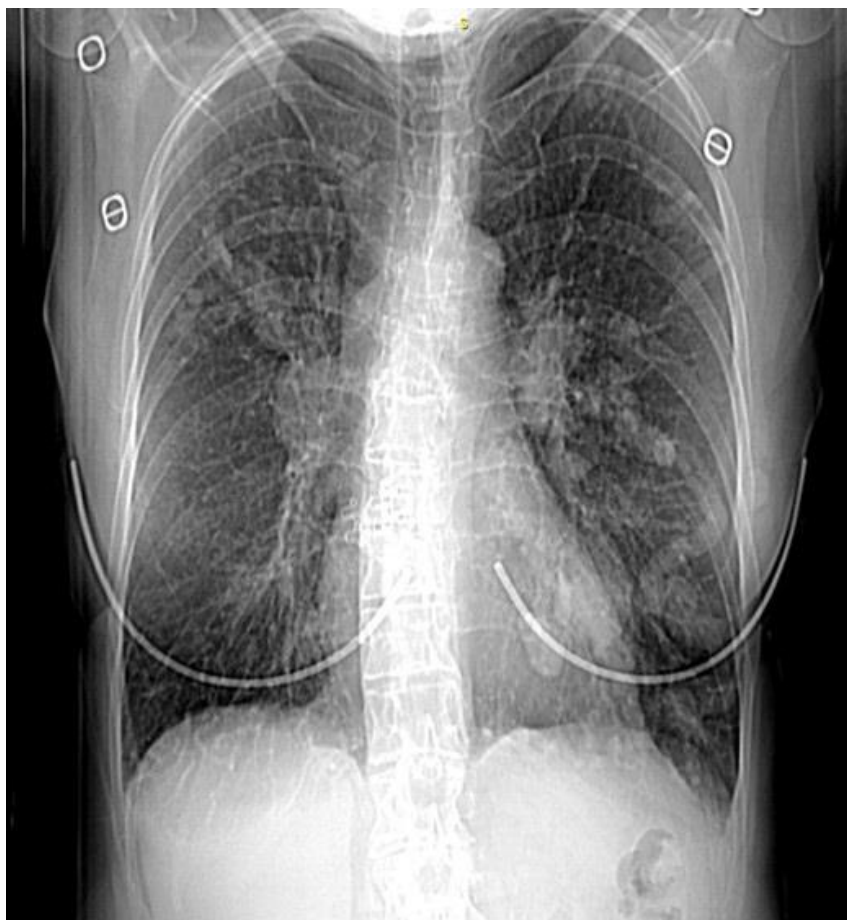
Initial PA chest radiograph.
